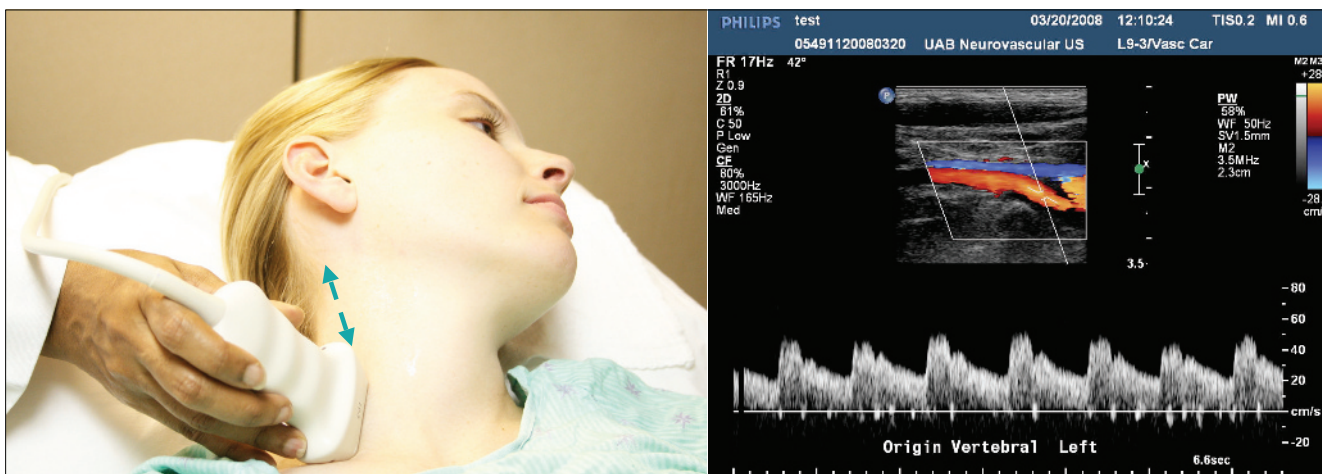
Doppler spectra in a proximal cervical segment of the vertebral artery visualized with B-mode and color flow.
